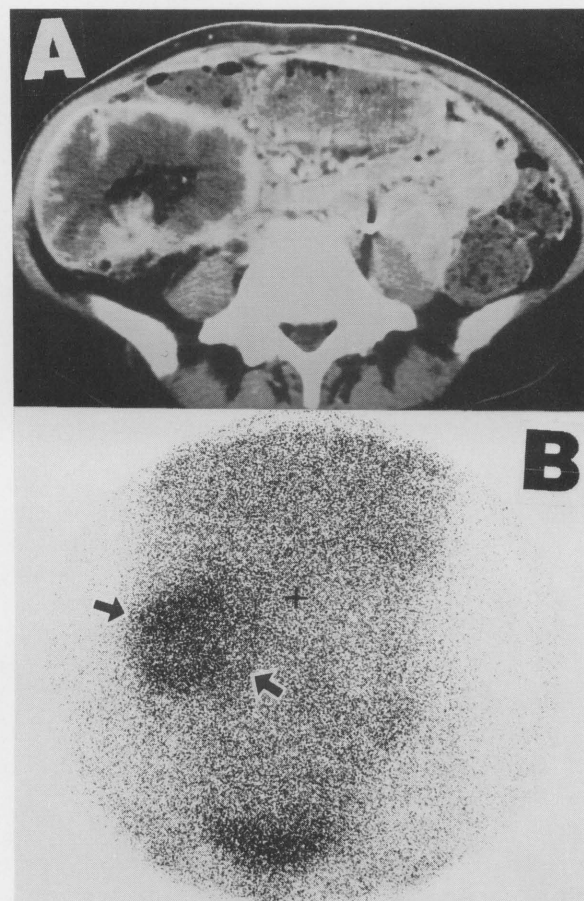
(A) CT shows large tumor in ascending colon measuring more than 8 cm. (B) Scintigraphy shows intense activity of radiotracer at the tumor site (arrows).
